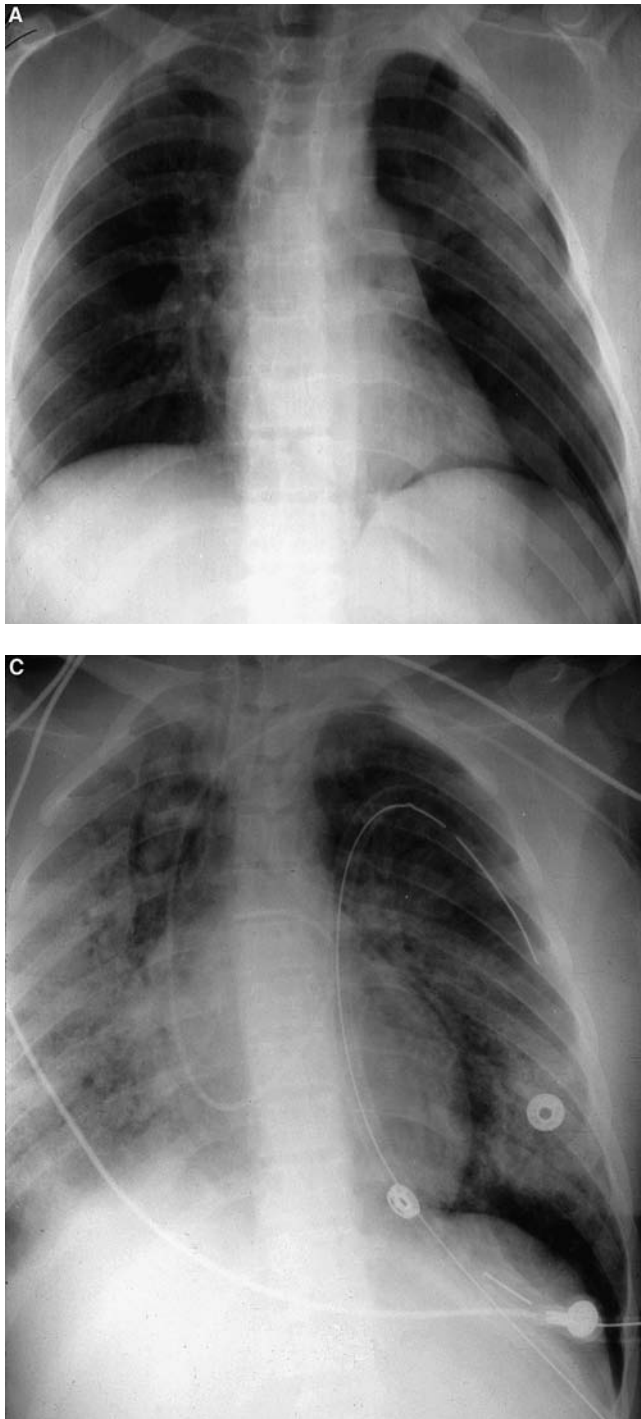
Sequential chest radiographs from an 18-year-old female who sustained a ruptured spleen, fractured clavicle, and other injuries during a motor vehicle accident. *A*, Day of admission: note minimal infiltrate in the periphery of the left lung. *B*, Three days later: “white-out” of both lungs characteristic of ARDS. *C*, Eighteen days after admission: large irregular densities alternate with lucent areas, characteristic of the fibroproliferative stage of ARDS. The patient died of respiratory failure secondary to fibrosis.
